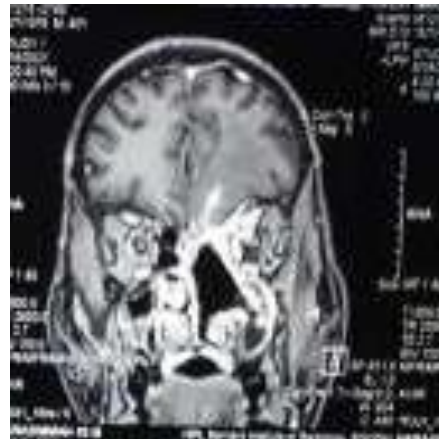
Pre Operative MRI Showing abscess in Left frontal lobe and Post Operative follow up MRI ,with no residual collection,inflammation.
